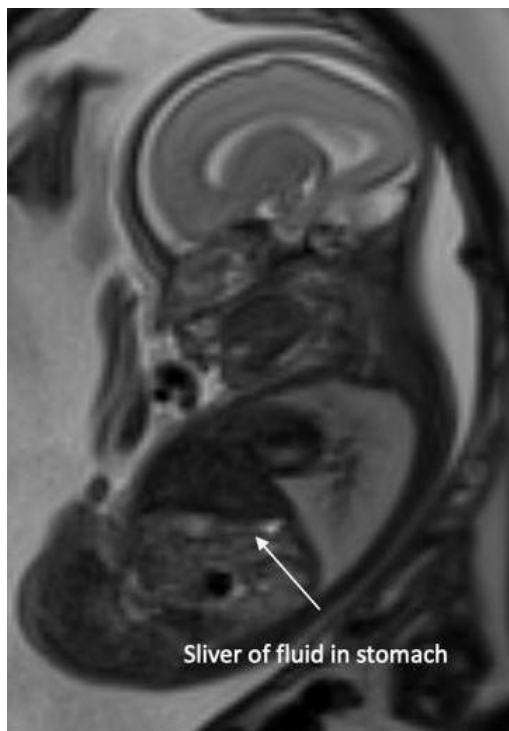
Sagittal T2 SSFSE fetal MRI image of 25 week fetus with a sliver of fluid visible in the stomach
